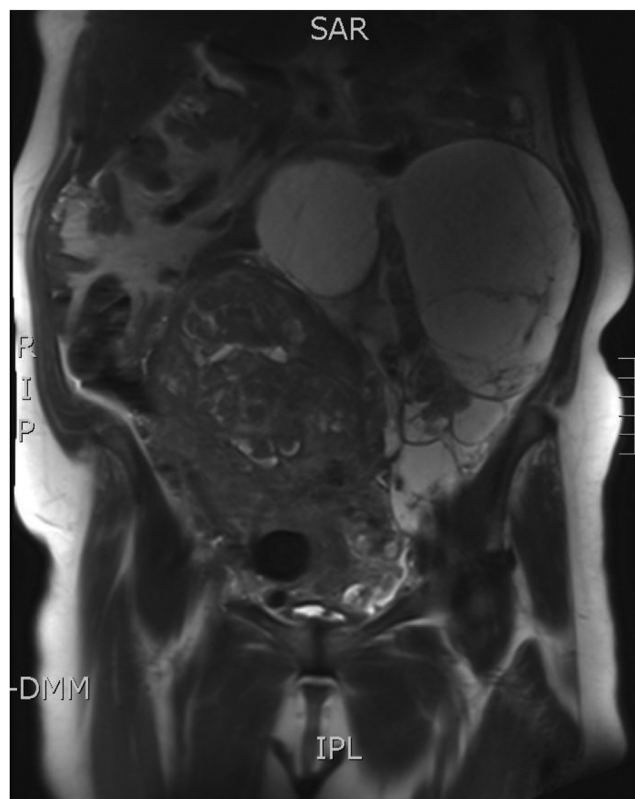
Pelvic MRI showing a huge uterine mass and a left adnexal complex cyst.
